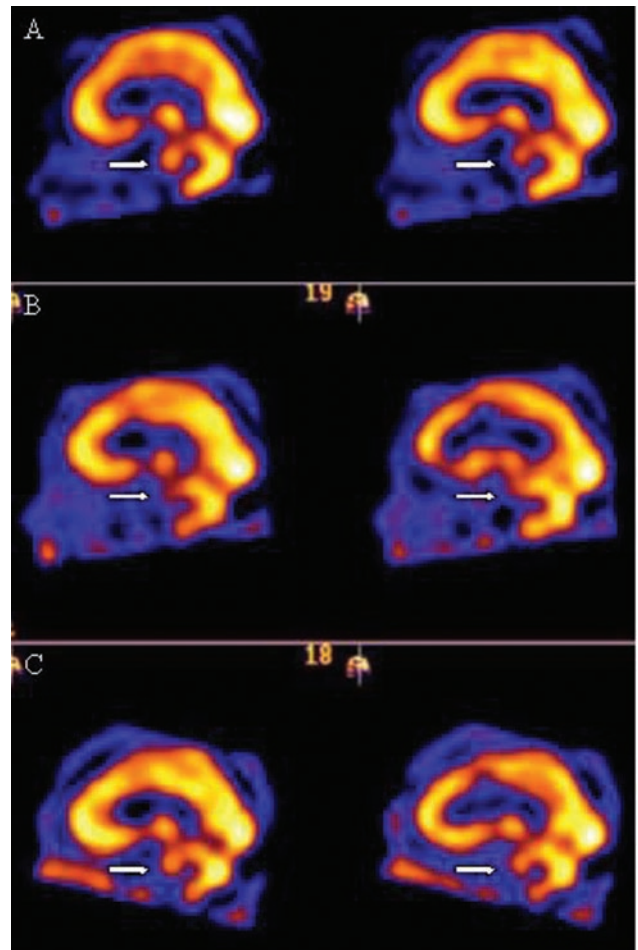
A 6-mm-thick sagittal plane reconstructed ^{99m}Tc SPECT imaging of a 54-year-old female with SAH after rupture of anterior communicating artery aneurysm. White arrows point to the BS (pons area). A, Baseline BS perfusion is normal, as can be seen by intense and bright uptake signal in the pons area (arrow), which is equal in intensity compared with the rest of the brain territories. B, On day 6 after the initial hemorrhage, the patient presented with RLC and elevated BA TCD-MFVs (145 cm/s). SPECT imaging disclosed severe reduction in the BS rCBF (arrows; note the disappearance of the pons uptake signal compared with baseline imaging [A]). C, The patient had angiography, which revealed severe (60%) diffuse narrowing of the BA and subsequently had balloon angioplasty. SPECT imaging obtained after angioplasty revealed significant improvement in BS rCBF perfusion (arrows; note reappearance of the pons uptake signal compared with baseline imaging [A]).
